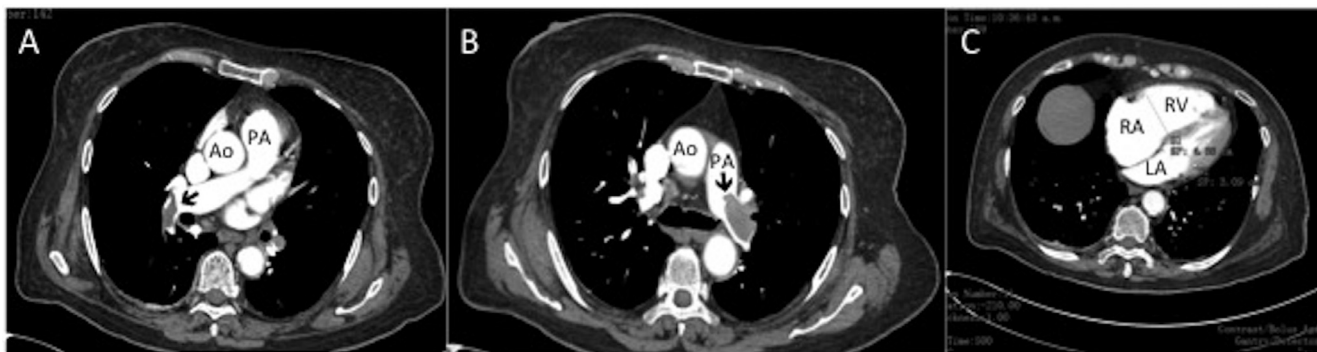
A,B- CT angiography showing thrombus (Black arrows) in the main, and subsegmental branches of the pumony artery. Ao, Aorta; LA, left ventricle; PA, pumony artery; RA, right atrium, RV, right ventricle.
